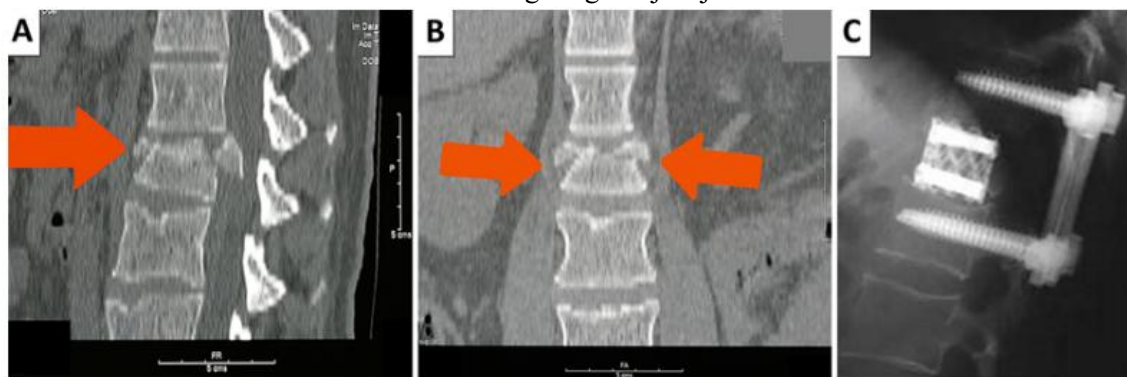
Example of vertebral compression fracture in the thoracolumbar segment after ejection. fighter aircraft. (A–B) CT scan shows L1 incomplete burst fracture in Panavia Tornado crew after ejection. (C) Postoperative radiograph after
